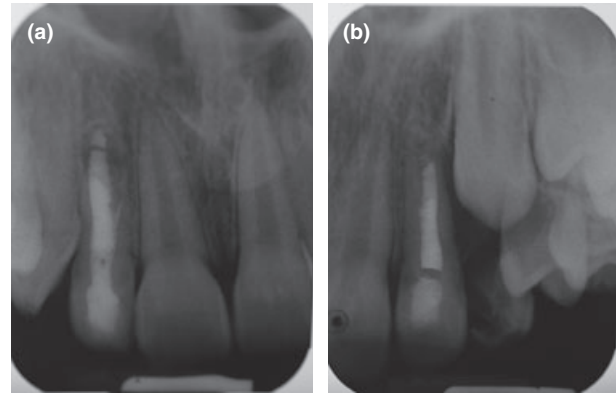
Radiographs showing position of non-ideal mineral trioxide aggregate (MTA) plugs associated with divergent apical anatomy: (a) Upper right lateral incisor shows overfill with MTA; (b) Upper left lateral incisor shows underfill with MTA.
